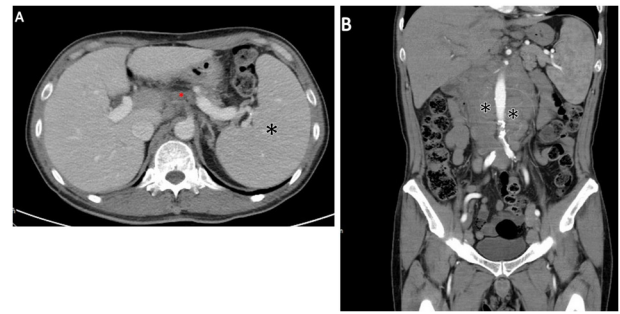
Initial abdominal CT. Dynamic CT images were obtained during non-enhanced and portal venous phase scan following intravenous contrast injection. Confluent enlarged lymph nodes over the gastrohepatic ligament, hepatoduodenal ligament, aorto-caval region, bilateral iliac chains and inguinal regions are visible. (A) In the aortic phase of the axial view, para-aortic lymphadenopathies were observed (red asterisk). Splenomegaly was also present (black asterisk). (B) In the aortic phase of the coronal view, mesenteric lymphadenopathies may be observed (black asterisks). CT, computed tomography.
